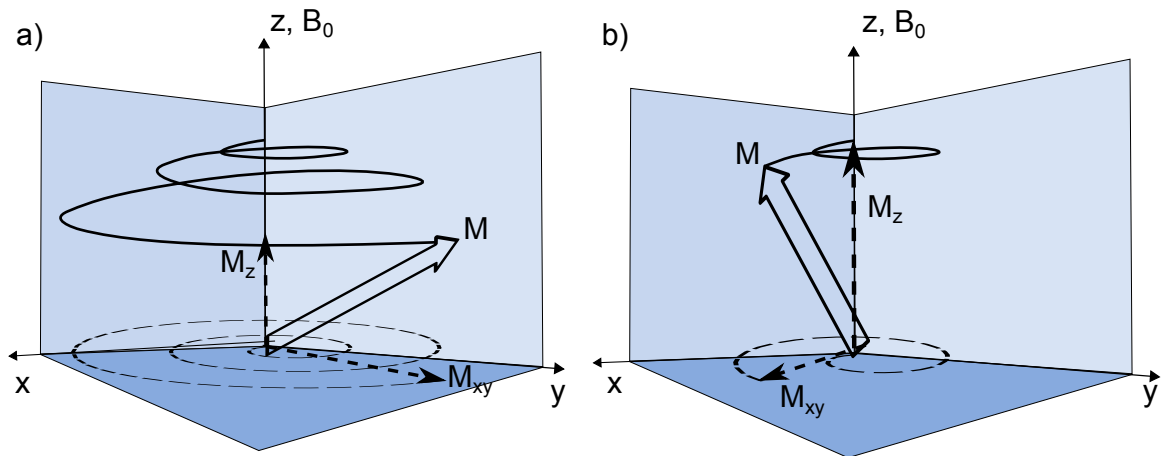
Relaxation of the macroscopic magnetization. (a) The component of  $\vec{M}$  in the transverse plane,  $M_{xy}$ , is responsible for all recorded signal in a MRI experiment. (b) The magnetization returns to its equilibrium condition  $M_0$  until another RF excitation pulse.
